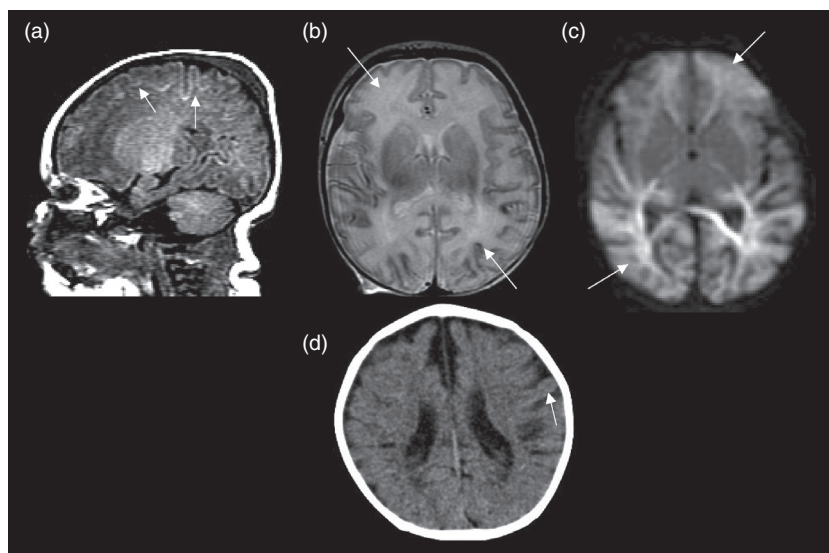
Partial prolonged HIE: acute phase with watershed injury (arrows) on (a) sagittal T1, (b) axial T2, and (c) axial DWI; (d) chronic phase with cortical atrophy and ulegyria (arrow) on axial CT.
